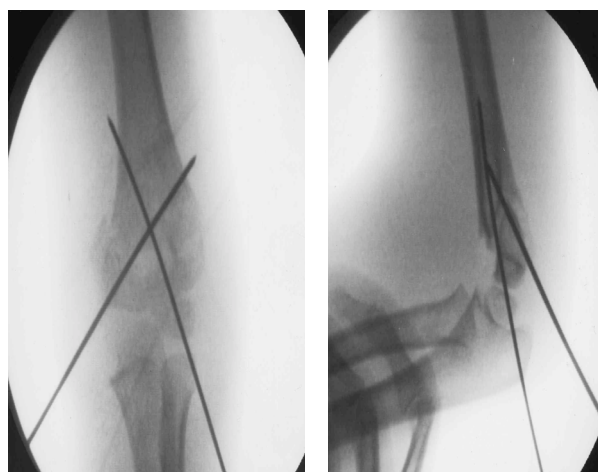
Intraoperative radiographs – closed repositioning of supracondylar fractures and with "K" wires stabilization.
